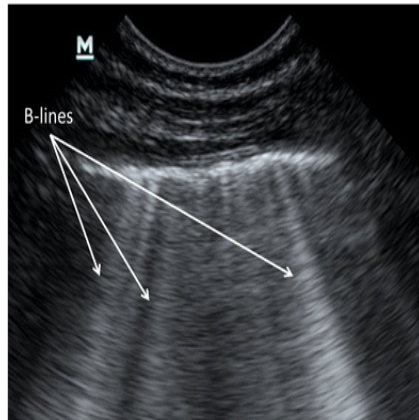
Pathologic Ultrasound: note the B lines in a child with Pneumonia
